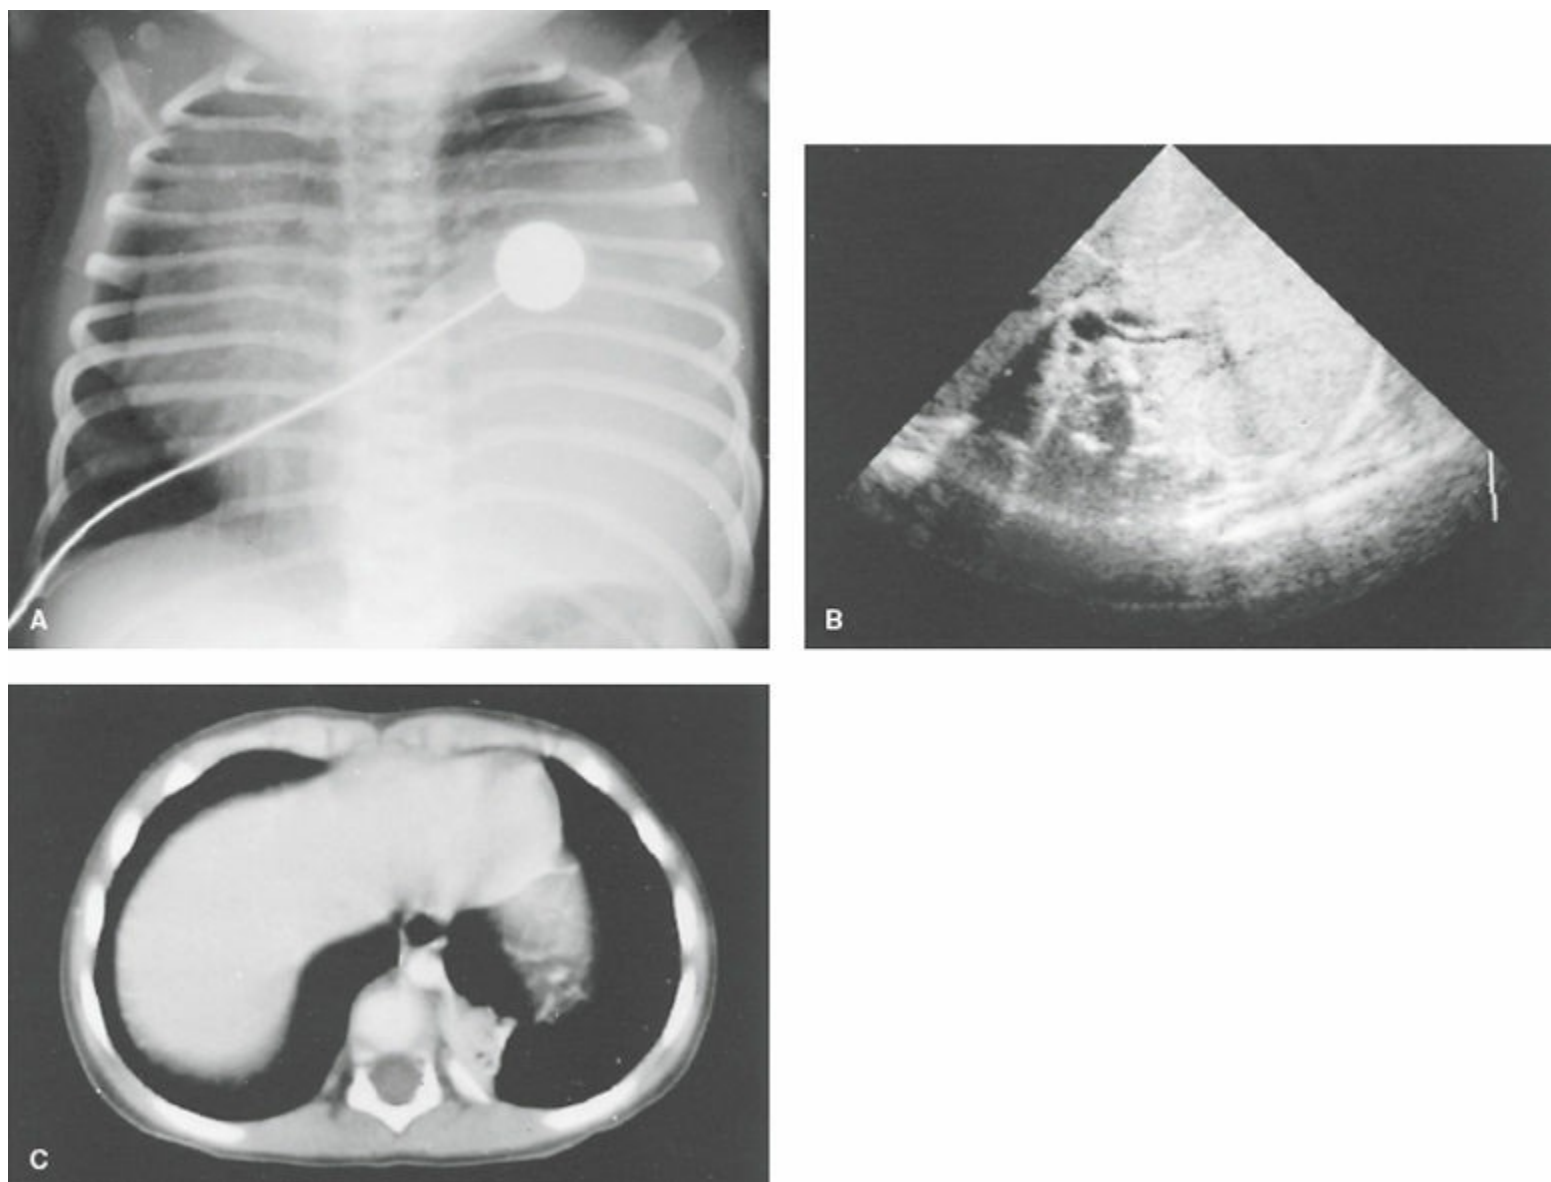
Abnormal radiograph of the chest of a newborn with respiratory distress (A). Ultrasound identified the anomalous vessel coursing through the diaphragm and entering the sequestration (B). This computed tomographic scan clearly demonstrates the anomalous artery arising from the thoracic aorta and entering the sequestered lung (C). (Reproduced with permission from Shields TW, ed. *General Thoracic Surgery*. 6th ed. 2005.)
